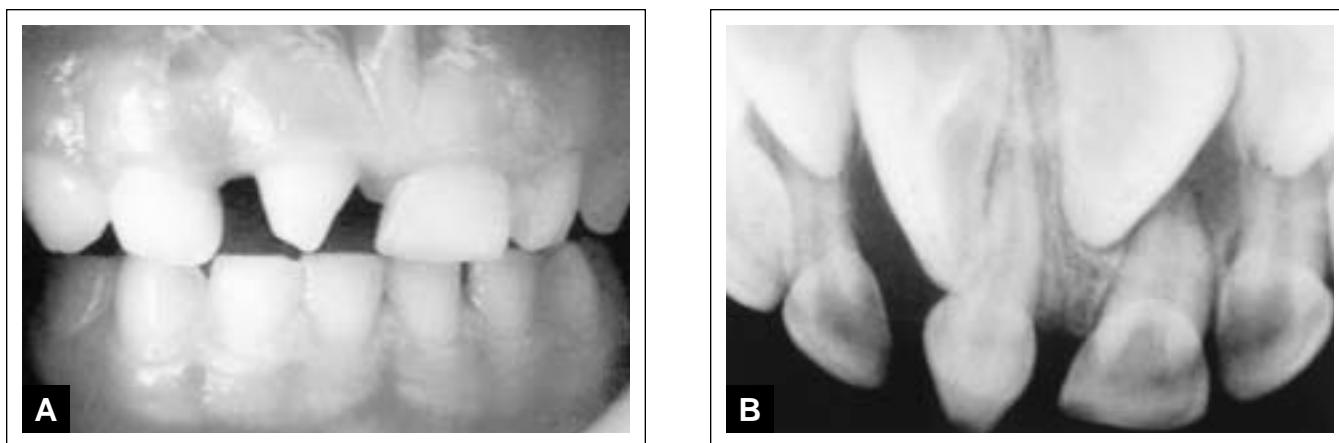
A) A peg-shaped mesiodens in primary dentition B) The periapical radiograph of the mesiodens.
